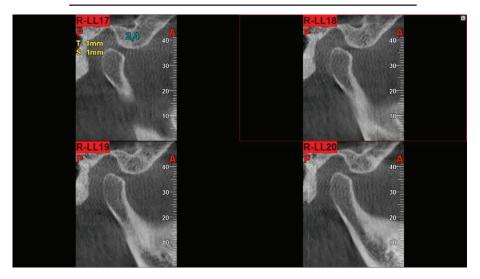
CT analysis of the patient's TMJ, born in 1968
